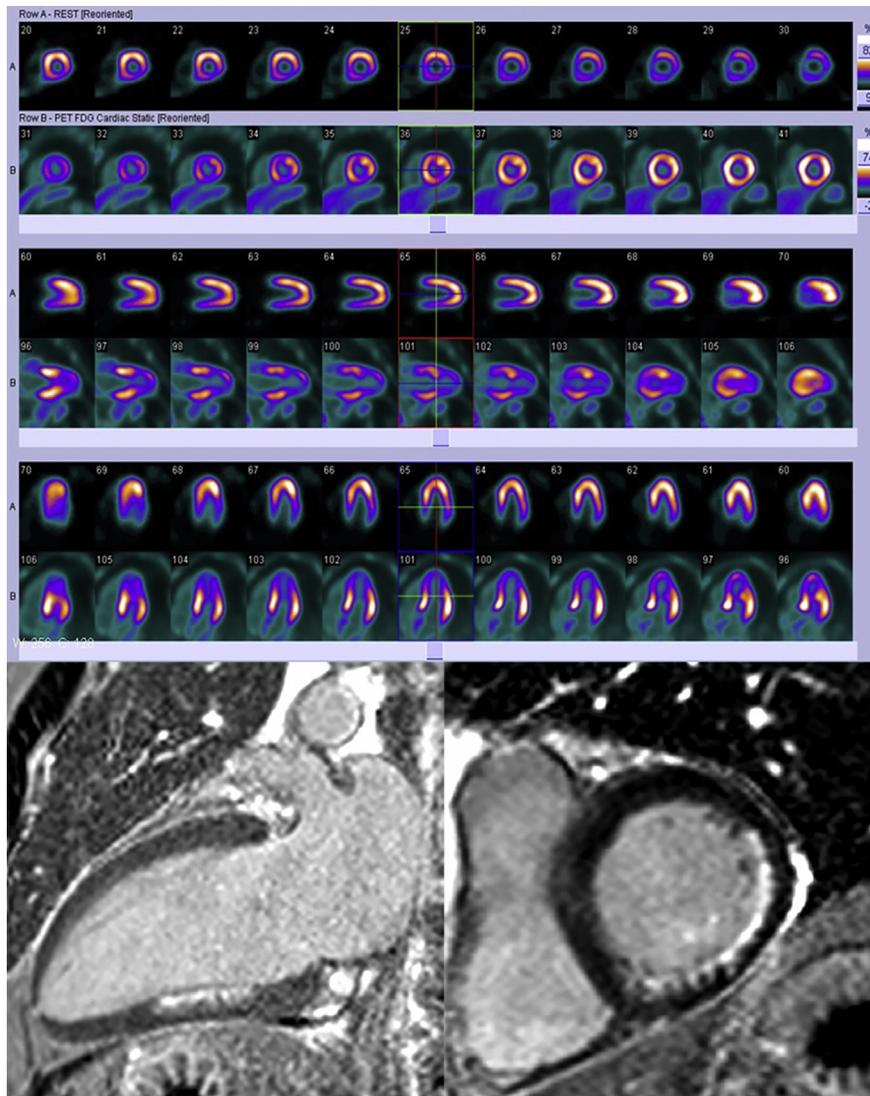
In a patient with chronic total occlusion of the right coronary artery, short axis and vertical long axis SPECT perfusion (top row) images showed a defect from the inferior wall to the posterolateral wall, and short axis and vertical long axis ^{18}F -FDG PET (bottom row) images showed a mild hypometabolism in corresponding myocardial segments (mismatched), short axis and vertical long axis cardiac MRI images showed that LGE of corresponding myocardial segments was 1–25%.
